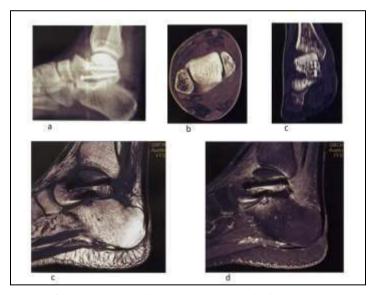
Osteonecrosis of Talus. X ray (a), CT (b and c), MRI T1 Sagittal (c), Post contrast Sagittal (d).
